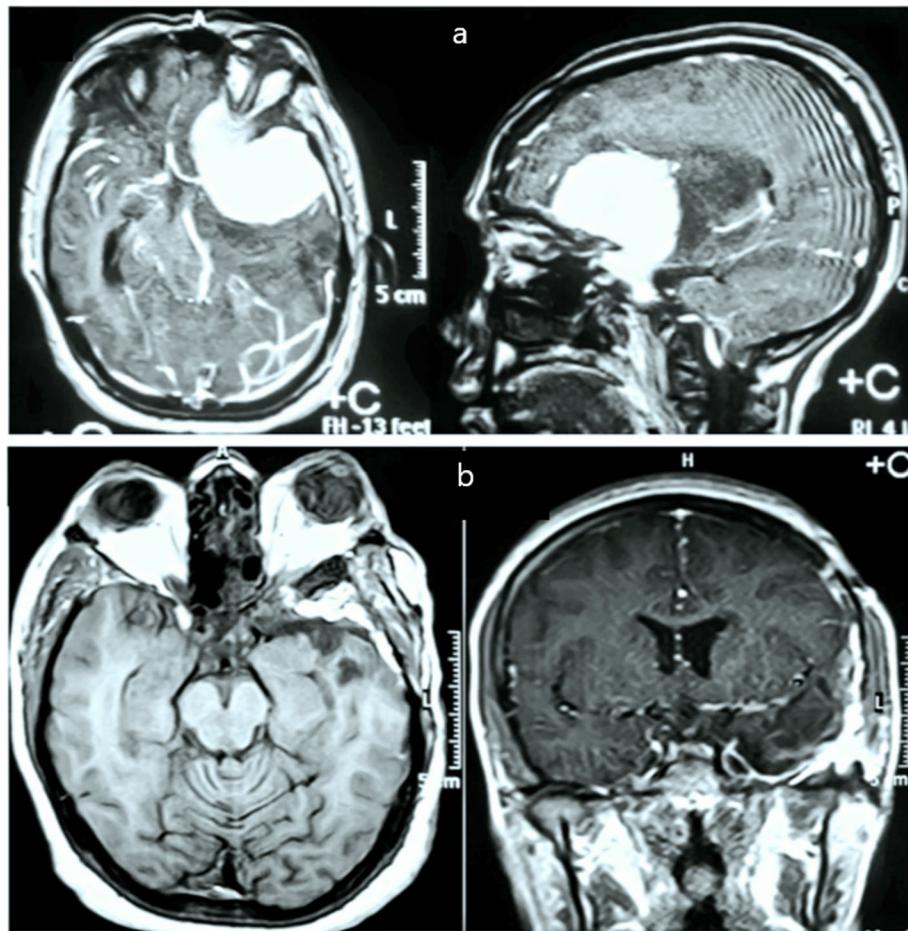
a, b Preoperative and postoperative imaging of case 2 with left ACM (type II). a Preoperative MRI with enhancement axial and sagittal view showing the displacement of the ICA bifurcation. b Postoperative MRI T1-weighted non-enhanced axial view and T1-weighted coronal view after contrast showing gross total resection and a hyperintense signal at the temporal pole explained by the fat and fascia lata graft used for the dura and the skull base repair
